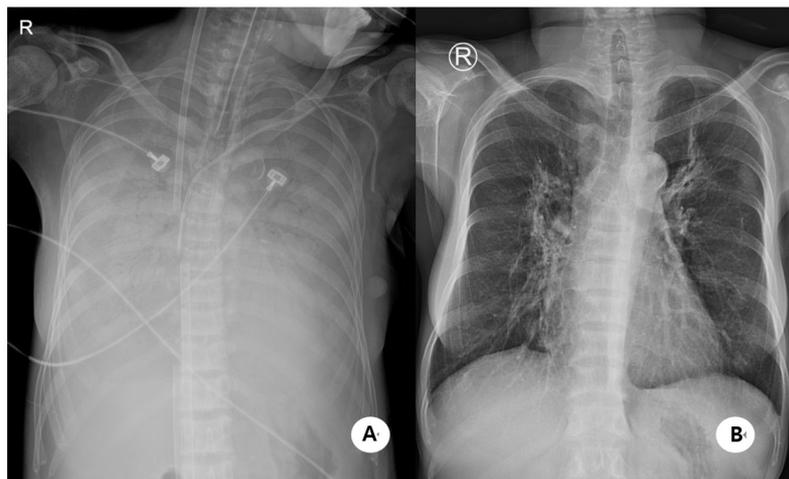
Chest imaging in patient with *Pneumocystis jirovecii* pneumonia. (A) Chest x-ray performed after extracorporeal membrane oxygenation (ECMO) placement on hospital day 9. (B) Three weeks after weaning from ECMO and discharge.^{4,5}
